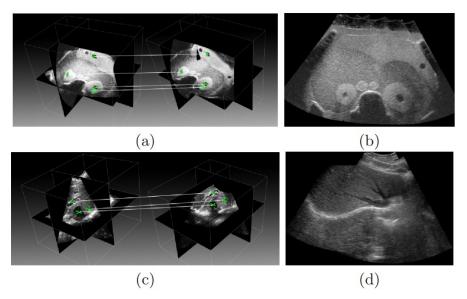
Example of a 3-dimensional ultrasound image being created (Ni, D., et al, 2008)
